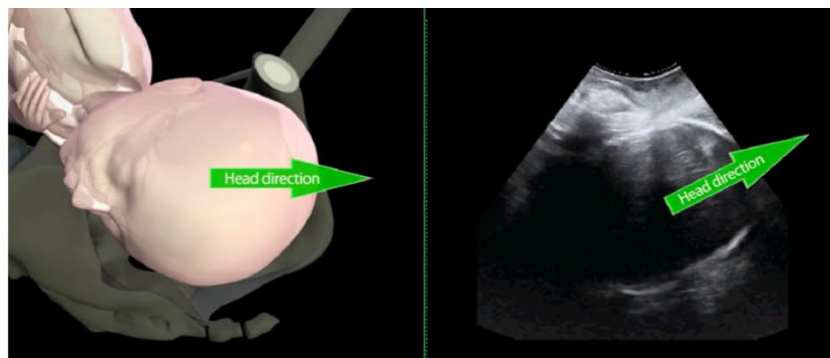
Measurement of head direction (adapted from ISUOG Practice Guidelines: intrapartum ultrasound)³
